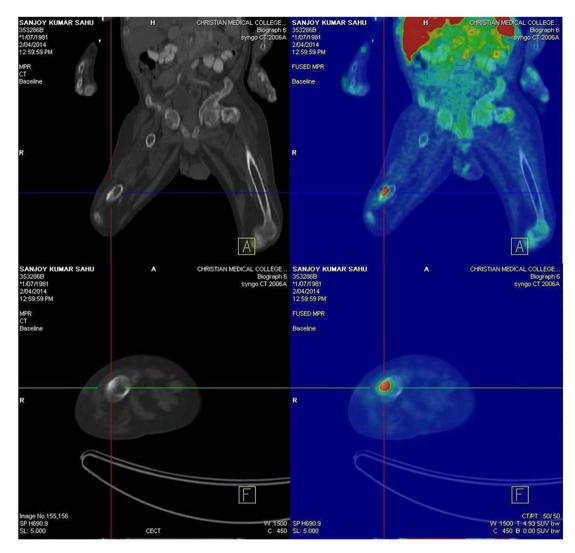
Ga68 DOTA TATE PET/CT (Patient no.3) showing uptake in distal end of shaft of right femur.
